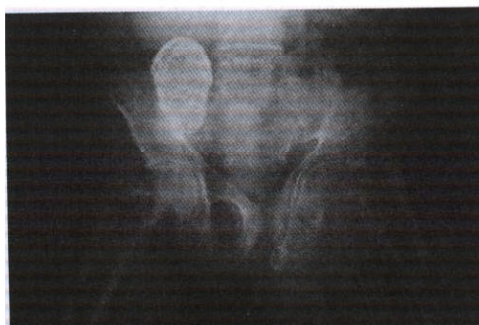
Pelvic X-ray: shows a calcified transplanted kidney in the right side of the pelvis, with triradiate pelvic deformity associated with left protusio acetabuli
